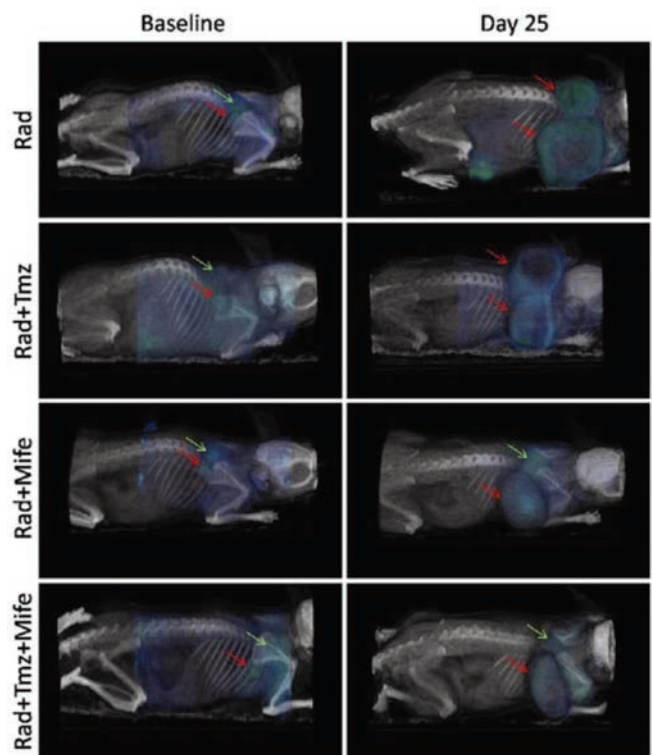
PET/CT images showing ^{18}F -FDG tumor uptake, in four treatment combinations, at the beginning of treatment and 25 days later. Red arrows indicate tumor location at baseline and day 25, green arrows show sites of typical ^{18}F -FDG uptake in brown adipose tissue (BAT). Reproduced from reference [1] in accordance with the Creative Commons License (<https://creativecommons.org/licenses/by/2.0/>).
